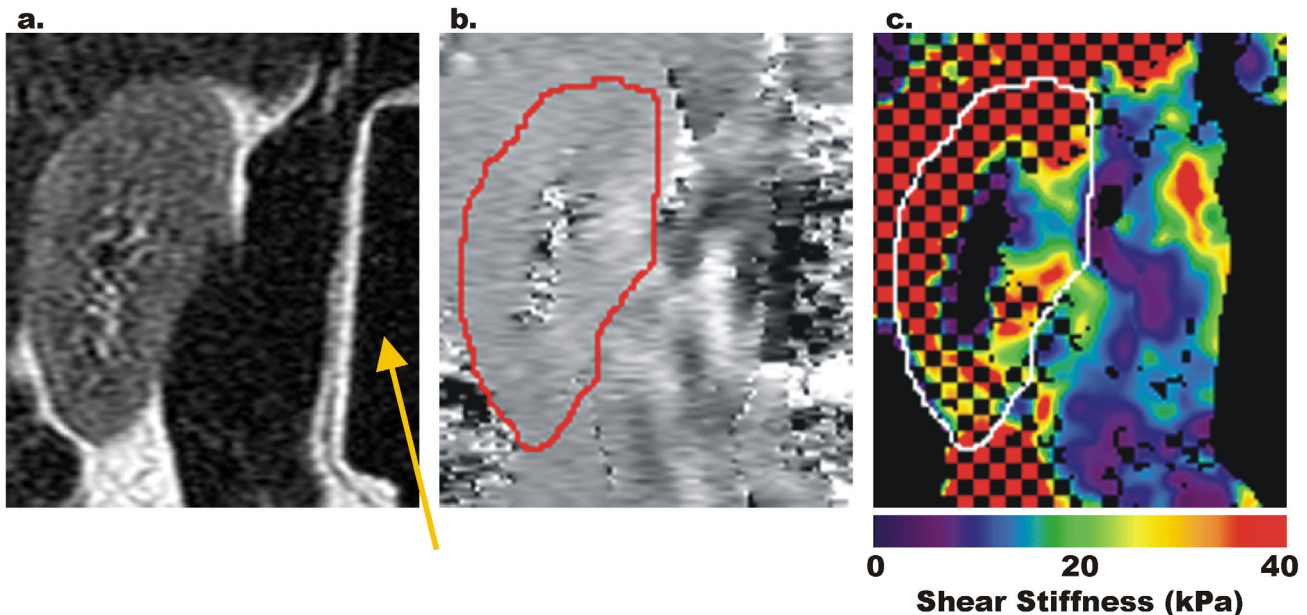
a. The sagittal T2-weighted FSE image shows the position of the “drum” driver (arrow). b. The wave image shows the displacement of the waves propagating into the kidney. c. The checked areas on the shear stiffness map represent regions with insufficient displacement SNR for accurate characterization.
